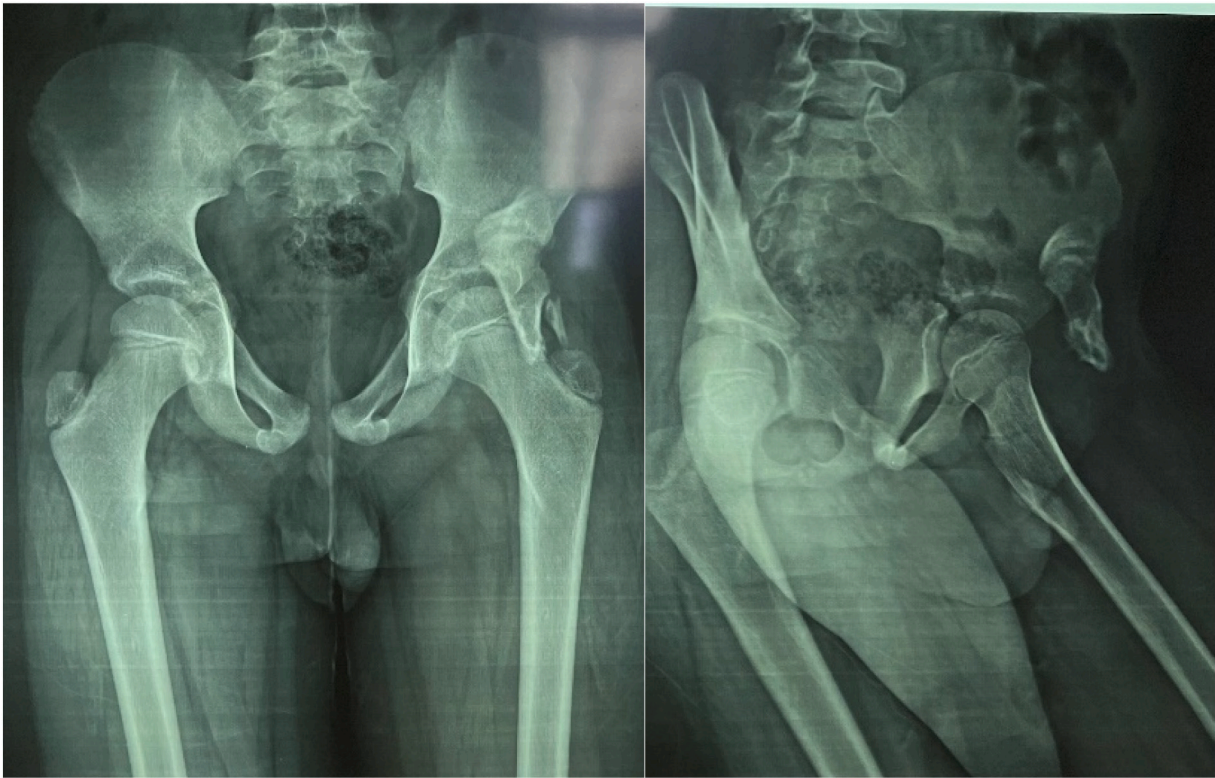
Plain x-ray shows no abnormalities but heterotopic ossification.
